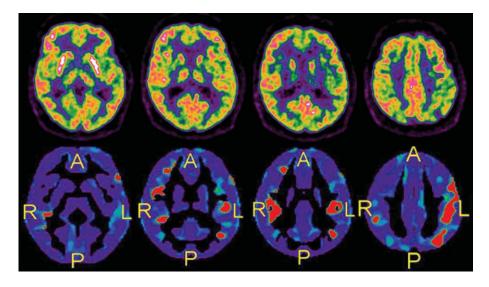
Example of AD hypometabolic pattern recognized by the expert and with a positive PALZ score (T-sum = 12,628) in a 64 year-old man with persistent aMCI after a 40-month follow-up. On top, FDG-PET visual analysis shows moderately reduced uptake in the left temporo-parietal cortex. On bottom, statistical PMOD maps also shows significant clusters within the AD hypometabolic pattern in left temporo-parietal cortex and right parietal cortex. Other details as in Fig. 1.
